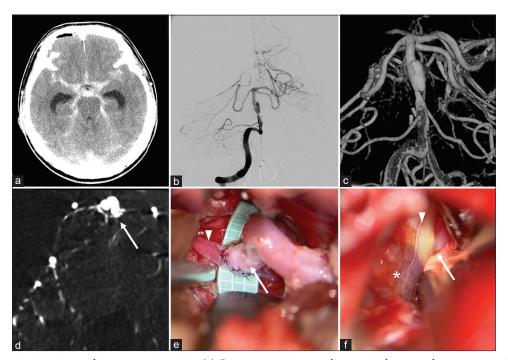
Preoperative imaging and intraoperative view. (a) Preoperative computed tomography scan showing a massive subarachnoid hemorrhage. (b) anteroposterior view of vertebral angiography showing spindle shaped aneurysmal changes of basilar artery (BA) between the bifurcations with the superior cerebellar artery (SCA) and anterior inferior cerebellar artery (AICA). (c) intimal flap and double-lumen sign were confirmed by 3-dimentional digital subtraction angiography (3D-DSA). (d) high-resolution CT showing perforators (arrow) originating from the dissecting artery. (e) intraoperative view: superficial temporal artery (arrow) -superior cerebellar artery (arrowhead) bypass. (f) intraoperative view: BA just proximall to origin of AICA (arrow) was almost normal (arrowhead) and there were no perforators nearby. BA distal to AICA was dissected (star).
